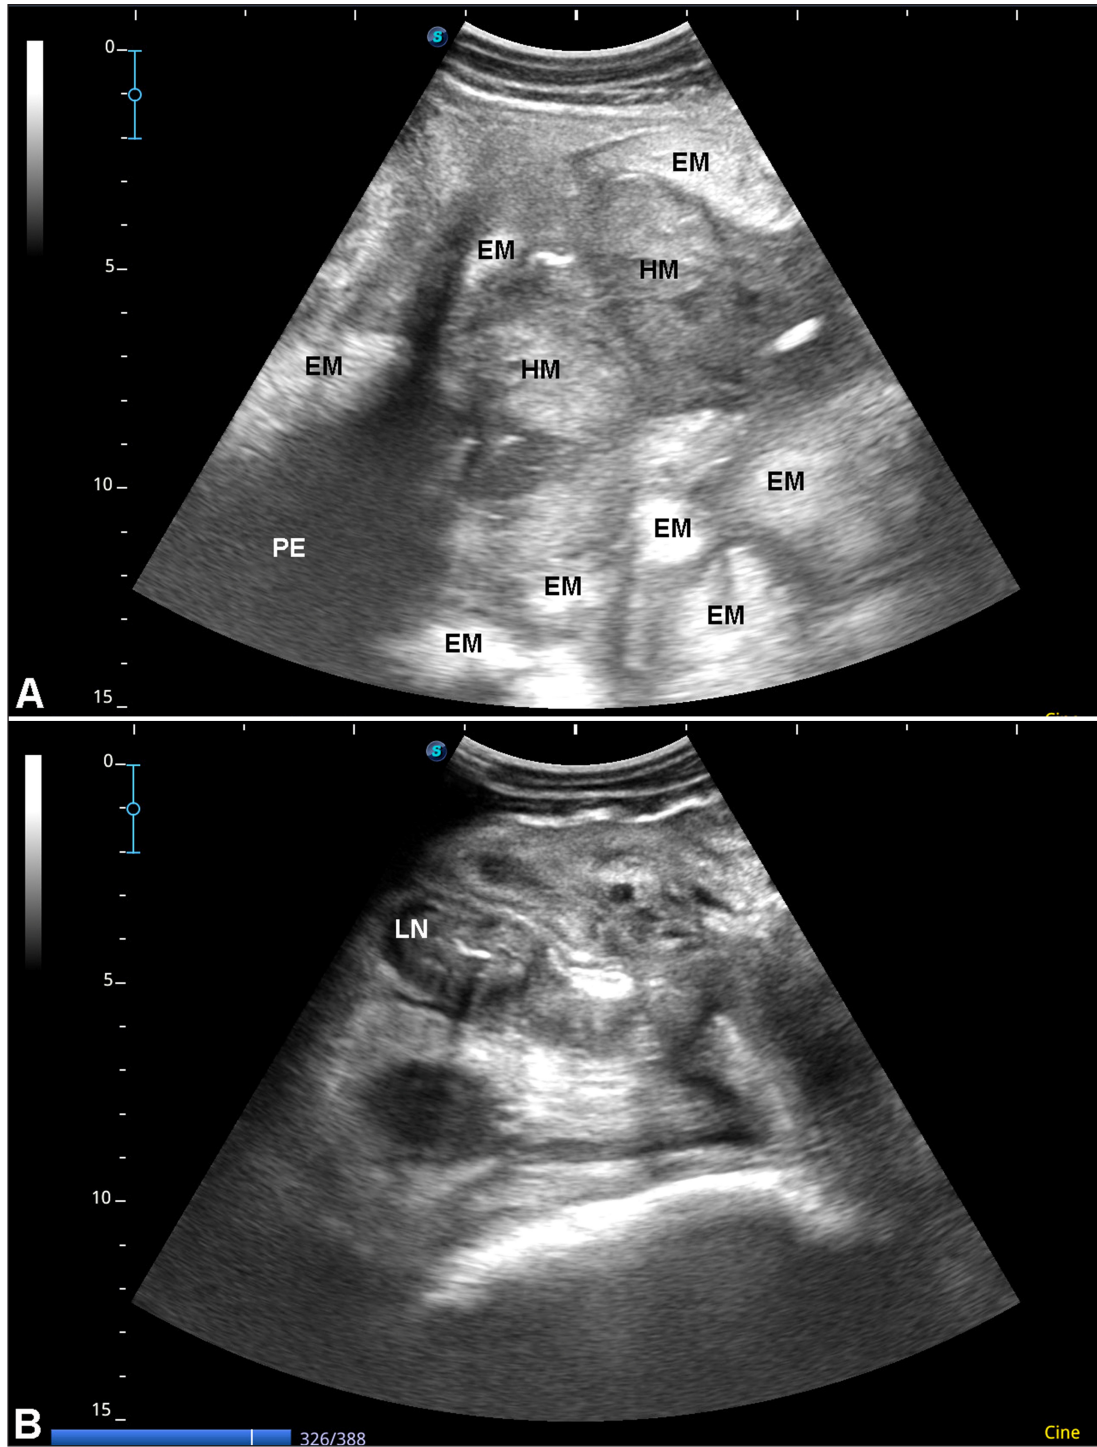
Ultrasonographic findings in a 7-year-old female dromedary camel with abdominal fat necrosis. Sonography of the right side of the abdomen showed multiple echogenic masses (EM) located within the intestinal loops; some of the masses are hypoechogenic (HM). Hyperechogenic peritoneal effusion (PE) was also imaged (A). Enlarged calcified mesenteric lymph nodes (LN) with distal acoustic shadowing was additional finding (B).
